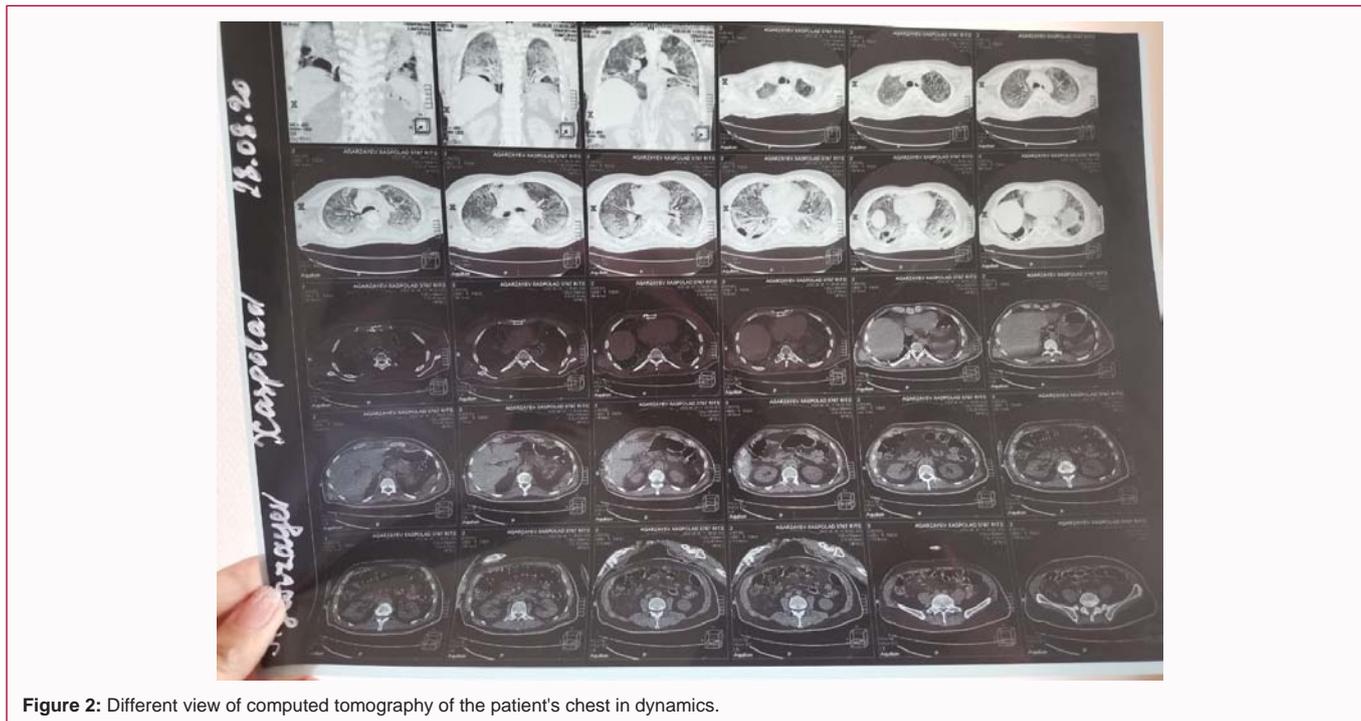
Different view of computed tomography of the patient's chest in dynamics.
